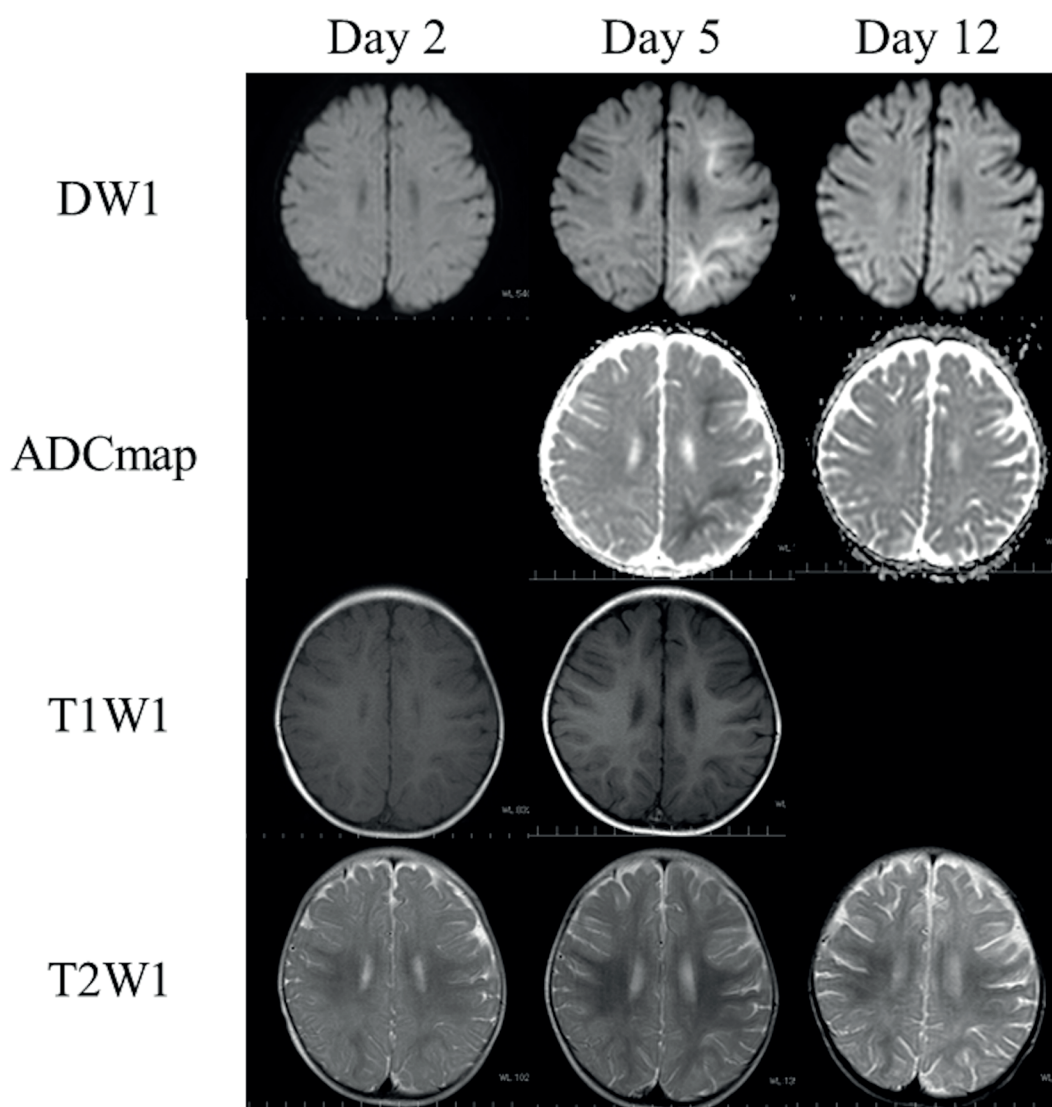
Magnetic resonance images of the brain.
